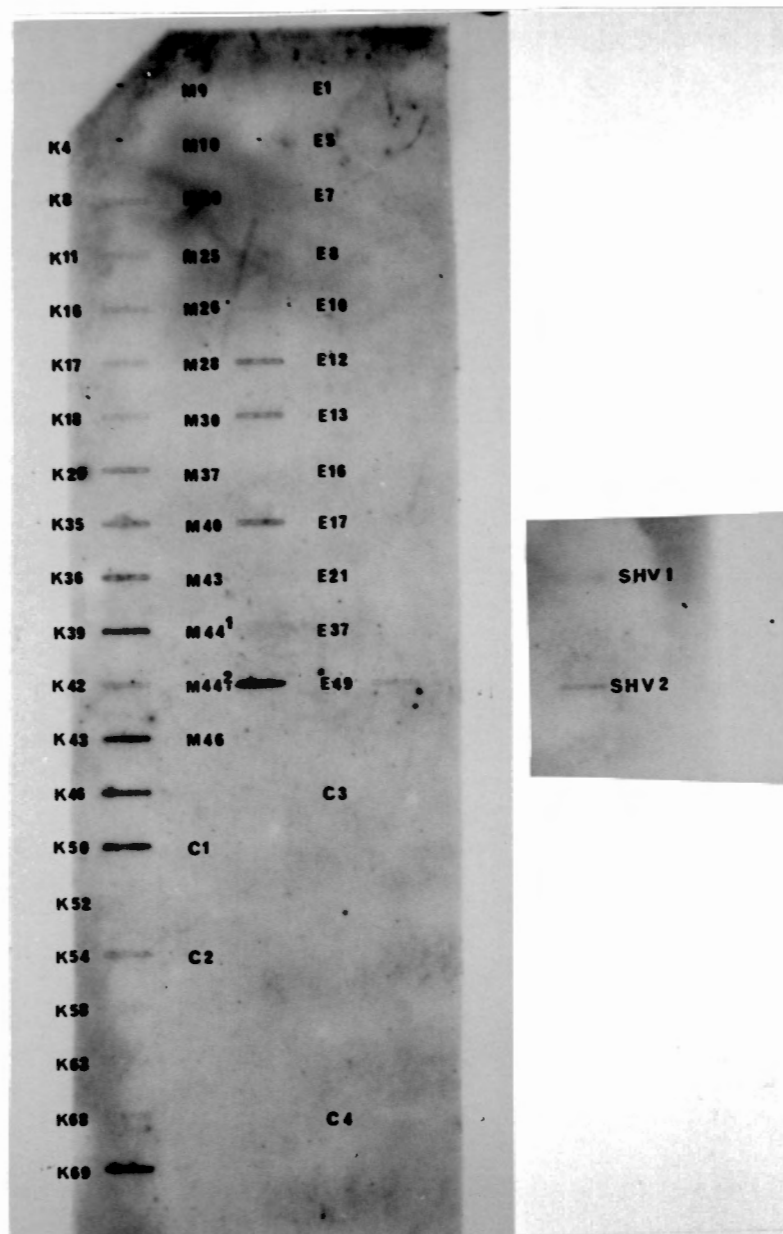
i Hybridisation of the SHV oligoprobe (ECL chemiluminescent label) to genomic DNA. The membrane was washed under low stringency conditions and exposed overnight to X-ray film (Curix RPI, Agfa).
